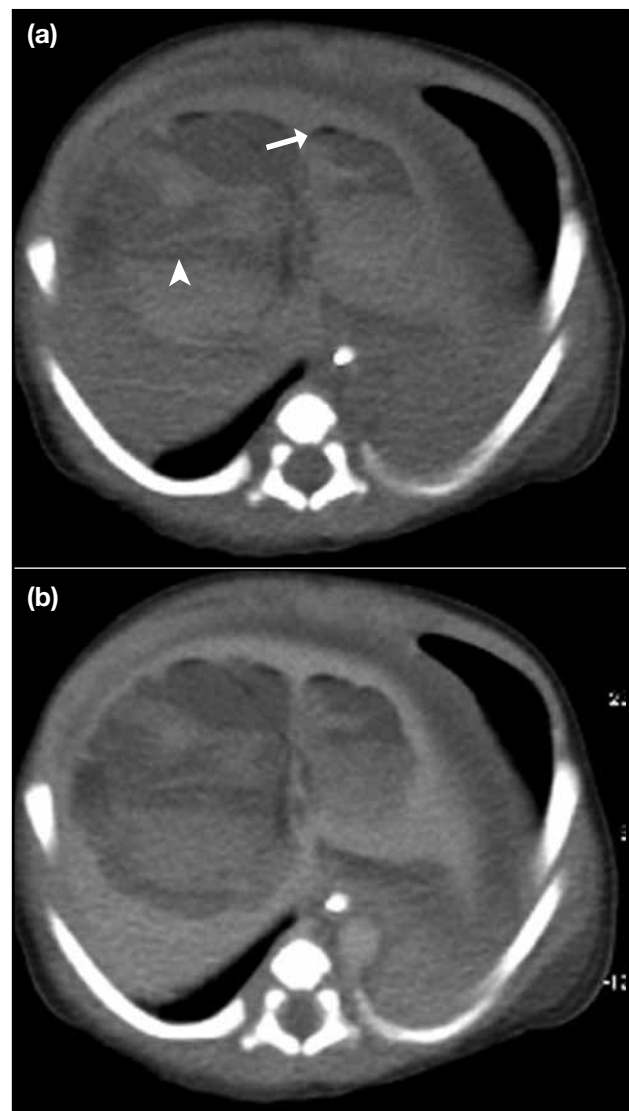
(a) Pre-contrast and (b) post-contrast computed tomographic liver: large space-occupying lesion in the liver with dependent hyperdense fluid-fluid level (arrowhead), compatible with haematoma. Antidependent hypodense foci are compatible with gas pockets (arrow), most likely secondary to previous umbilical venous catheterization.
